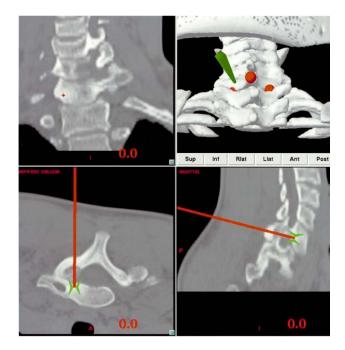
(Top) Axial computed tomography image demonstrating well-circumscribed lytic lesion in cervical pedicle, with erosion of medial cortex into the neural canal. (Middle) Intraoperative stereotactic image after registration, showing probe tip over cortical entry point providing optimal access to osteoid osteoma. (Bottom) Intraoperative stereotactic image demonstrating probe tip at base of void created during excision of tumor nidus. Stereotactic image guidance permitted complete ablation of tumor without risk of entry into the canal.
